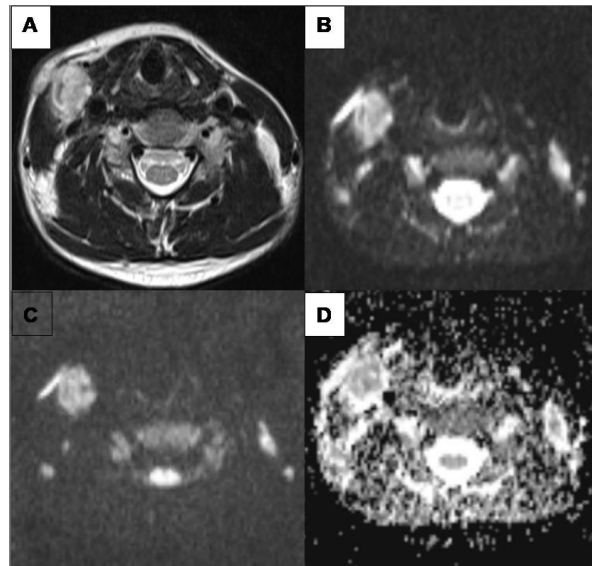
Tubercular cervical lymph node. Axial T2W MR image (A) showing enlarged right level II lymph node with mixed SI. Enlarged right level II lymph node show high SI on DW-MRI image at $b=0$ s/mm² (B) and $b=1,000$ s/mm² (C). Enlarged right level II lymph node shows mixed SI on ADC map (D). The mean ADC value of the right level II lymph node is $1.03 \pm 0.23 \times 10^{-3}$ mm²/s
